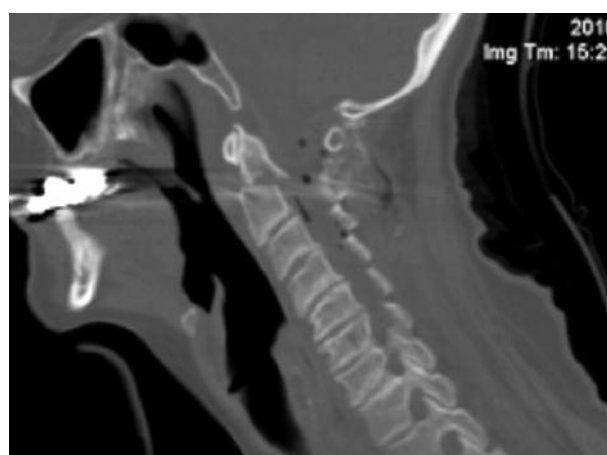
(a) 64-year-old woman had atlantoaxial instability with type 2 dens fracture (with rupture of the atlas ligament). (b) Sagittal cervical CT showed TAS fixation and cancellous grafts could be recognized 1 year after operation.
